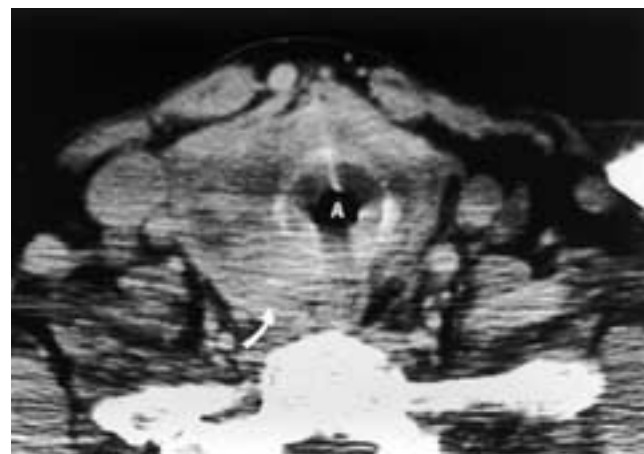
Riedel's thyroiditis (struma). An axial CT scan shows slight enlargement of the thyroid gland with multiple areas of poorly defined hypodensity. Note the associated narrowing of the subglottic airway (A), as well as obliteration of the fat in the right tracheoesophageal groove (arrow).
